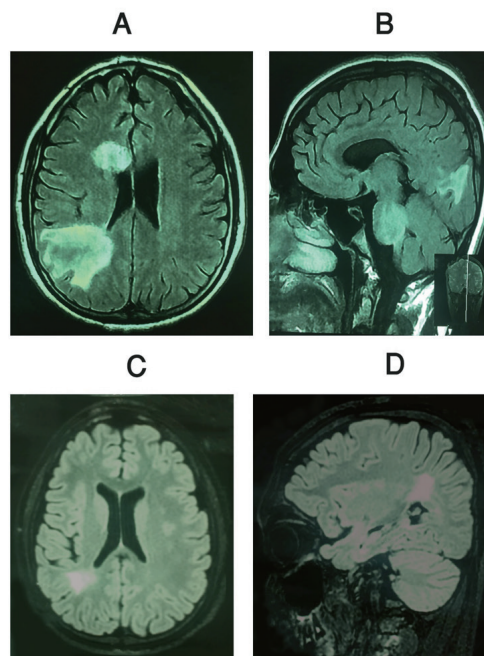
a, b. Brain MRI revealed tumefactive demyelinating lesions. c, d. Follow up MRI showed an obvious recovery.
